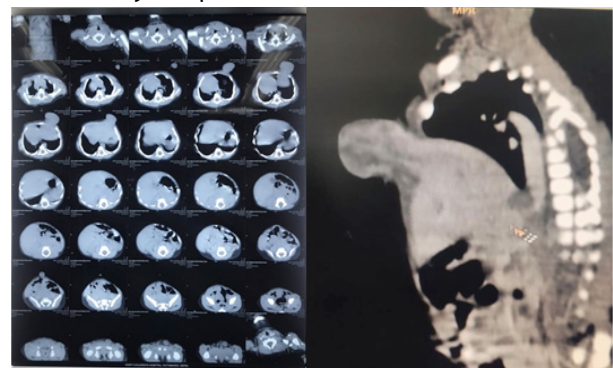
Pre-operative contrast enhanced CT scan of abdomen and pelvis
